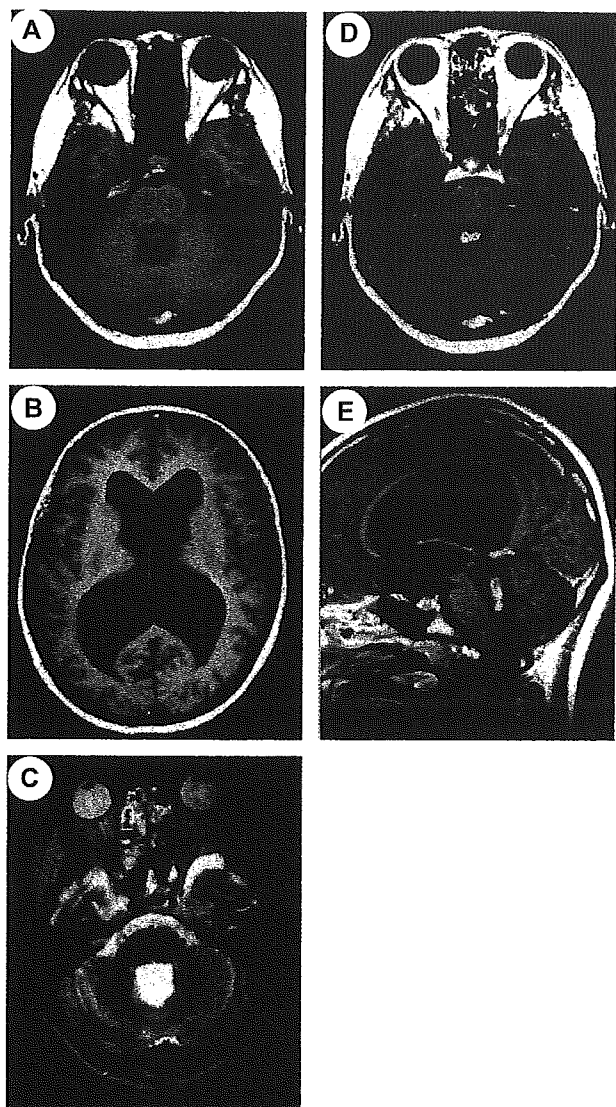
Magnetic resonance imaging scans on admission. A and B: Axial T1-weighted MRI showing a low-intensity mass in the fourth ventricle and enlargement of the lateral ventricles. C: Axial T2-weighted MRI visualizing the mass as an area of high intensity. D and E: Axial (D) and sagittal (E) T1-weighted MRI scans obtained after the injection of gadolinium-diethylenetriamine pentaacetic acid show enhancement of the center portion of the mass.
